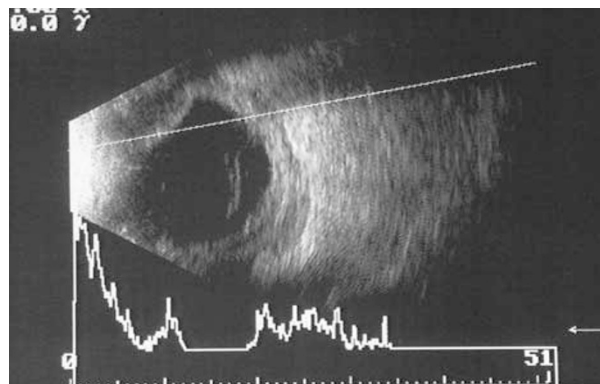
Ultrasound scan showing posterior scleral thickening and an anterior choroidal detachment.
